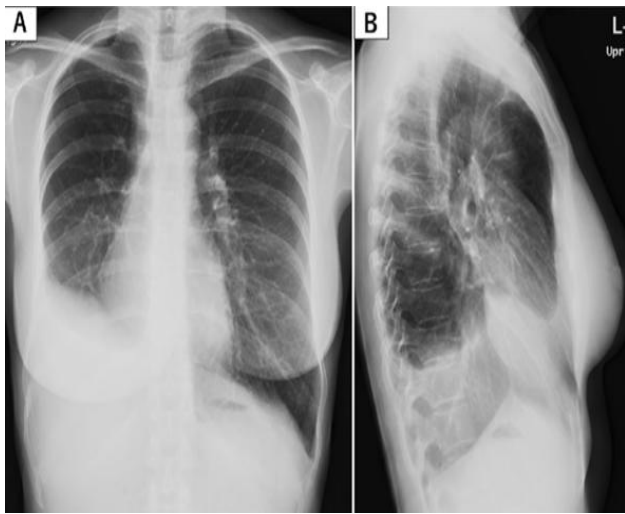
(A and B): Chest X-ray in 2 projections taken 1 year after surgery.
